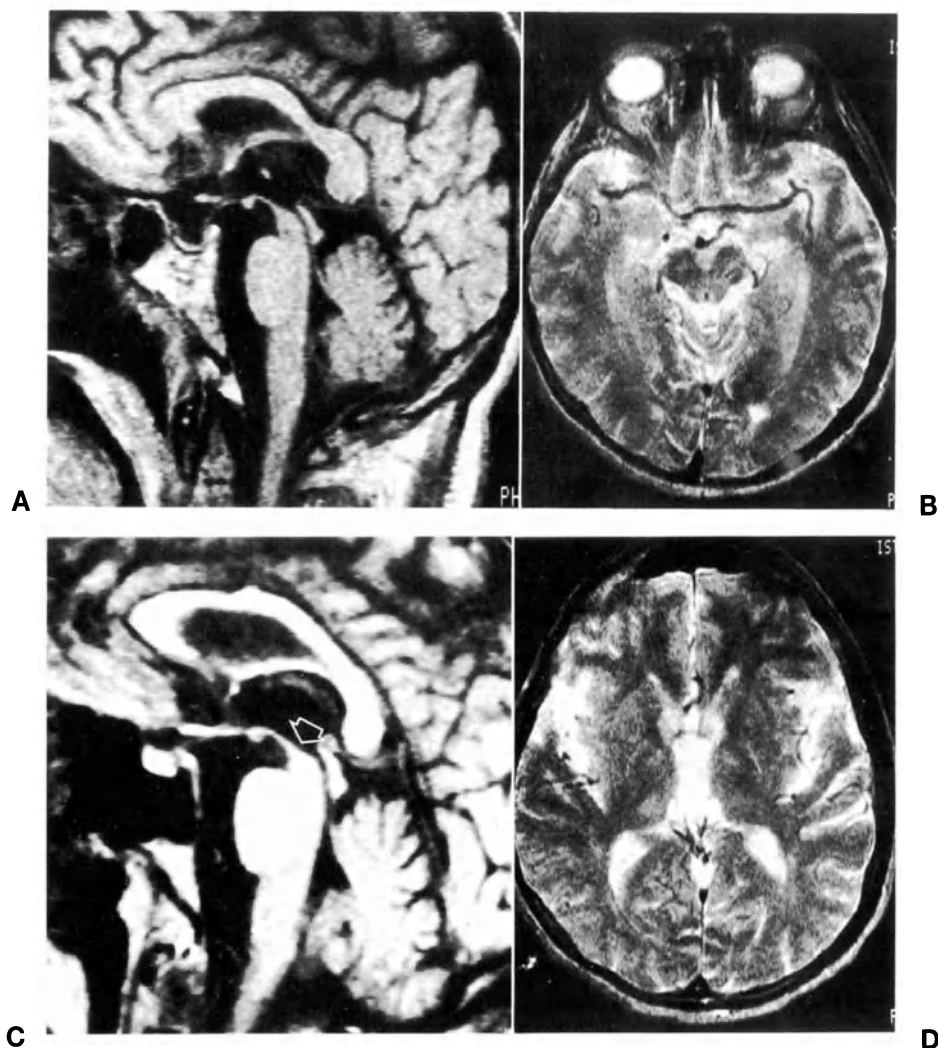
Progressive supranuclear palsy. Sagittal T1-weighted images demonstrate definite midbrain atrophy in about half of the cases (A); atrophy of the dorsal midbrain is also recognizable in axial sections (B T2-weighted image). Hyperextension of the head may be present (C); atrophy involving the brain tissue around the third ventricle also causes an inferior convexity of the floor of the third ventricle (open arrow, C sagittal T1-weighted section), and a disproportionate enlargement of the third ventricle compared to the lateral ventricles (D axial T2-weighted image)
